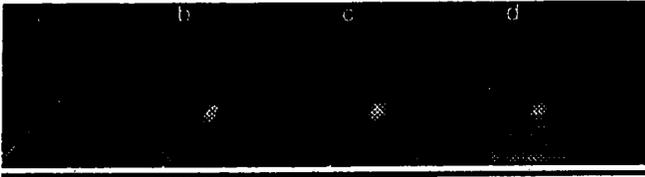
A feature space sequence generated from two similar MR images registered (a) and translated laterally by 3mm (b), 9mm (c) and 25mm (d).
